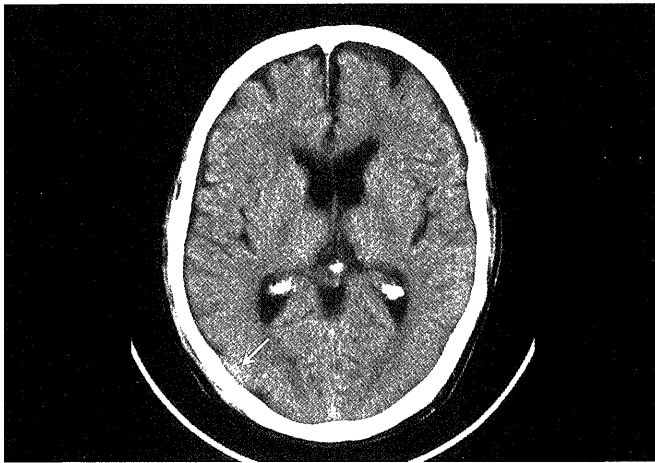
Initial CT scan showing minute abnormality in the right parietal bone (arrow), only appreciated retrospectively.
